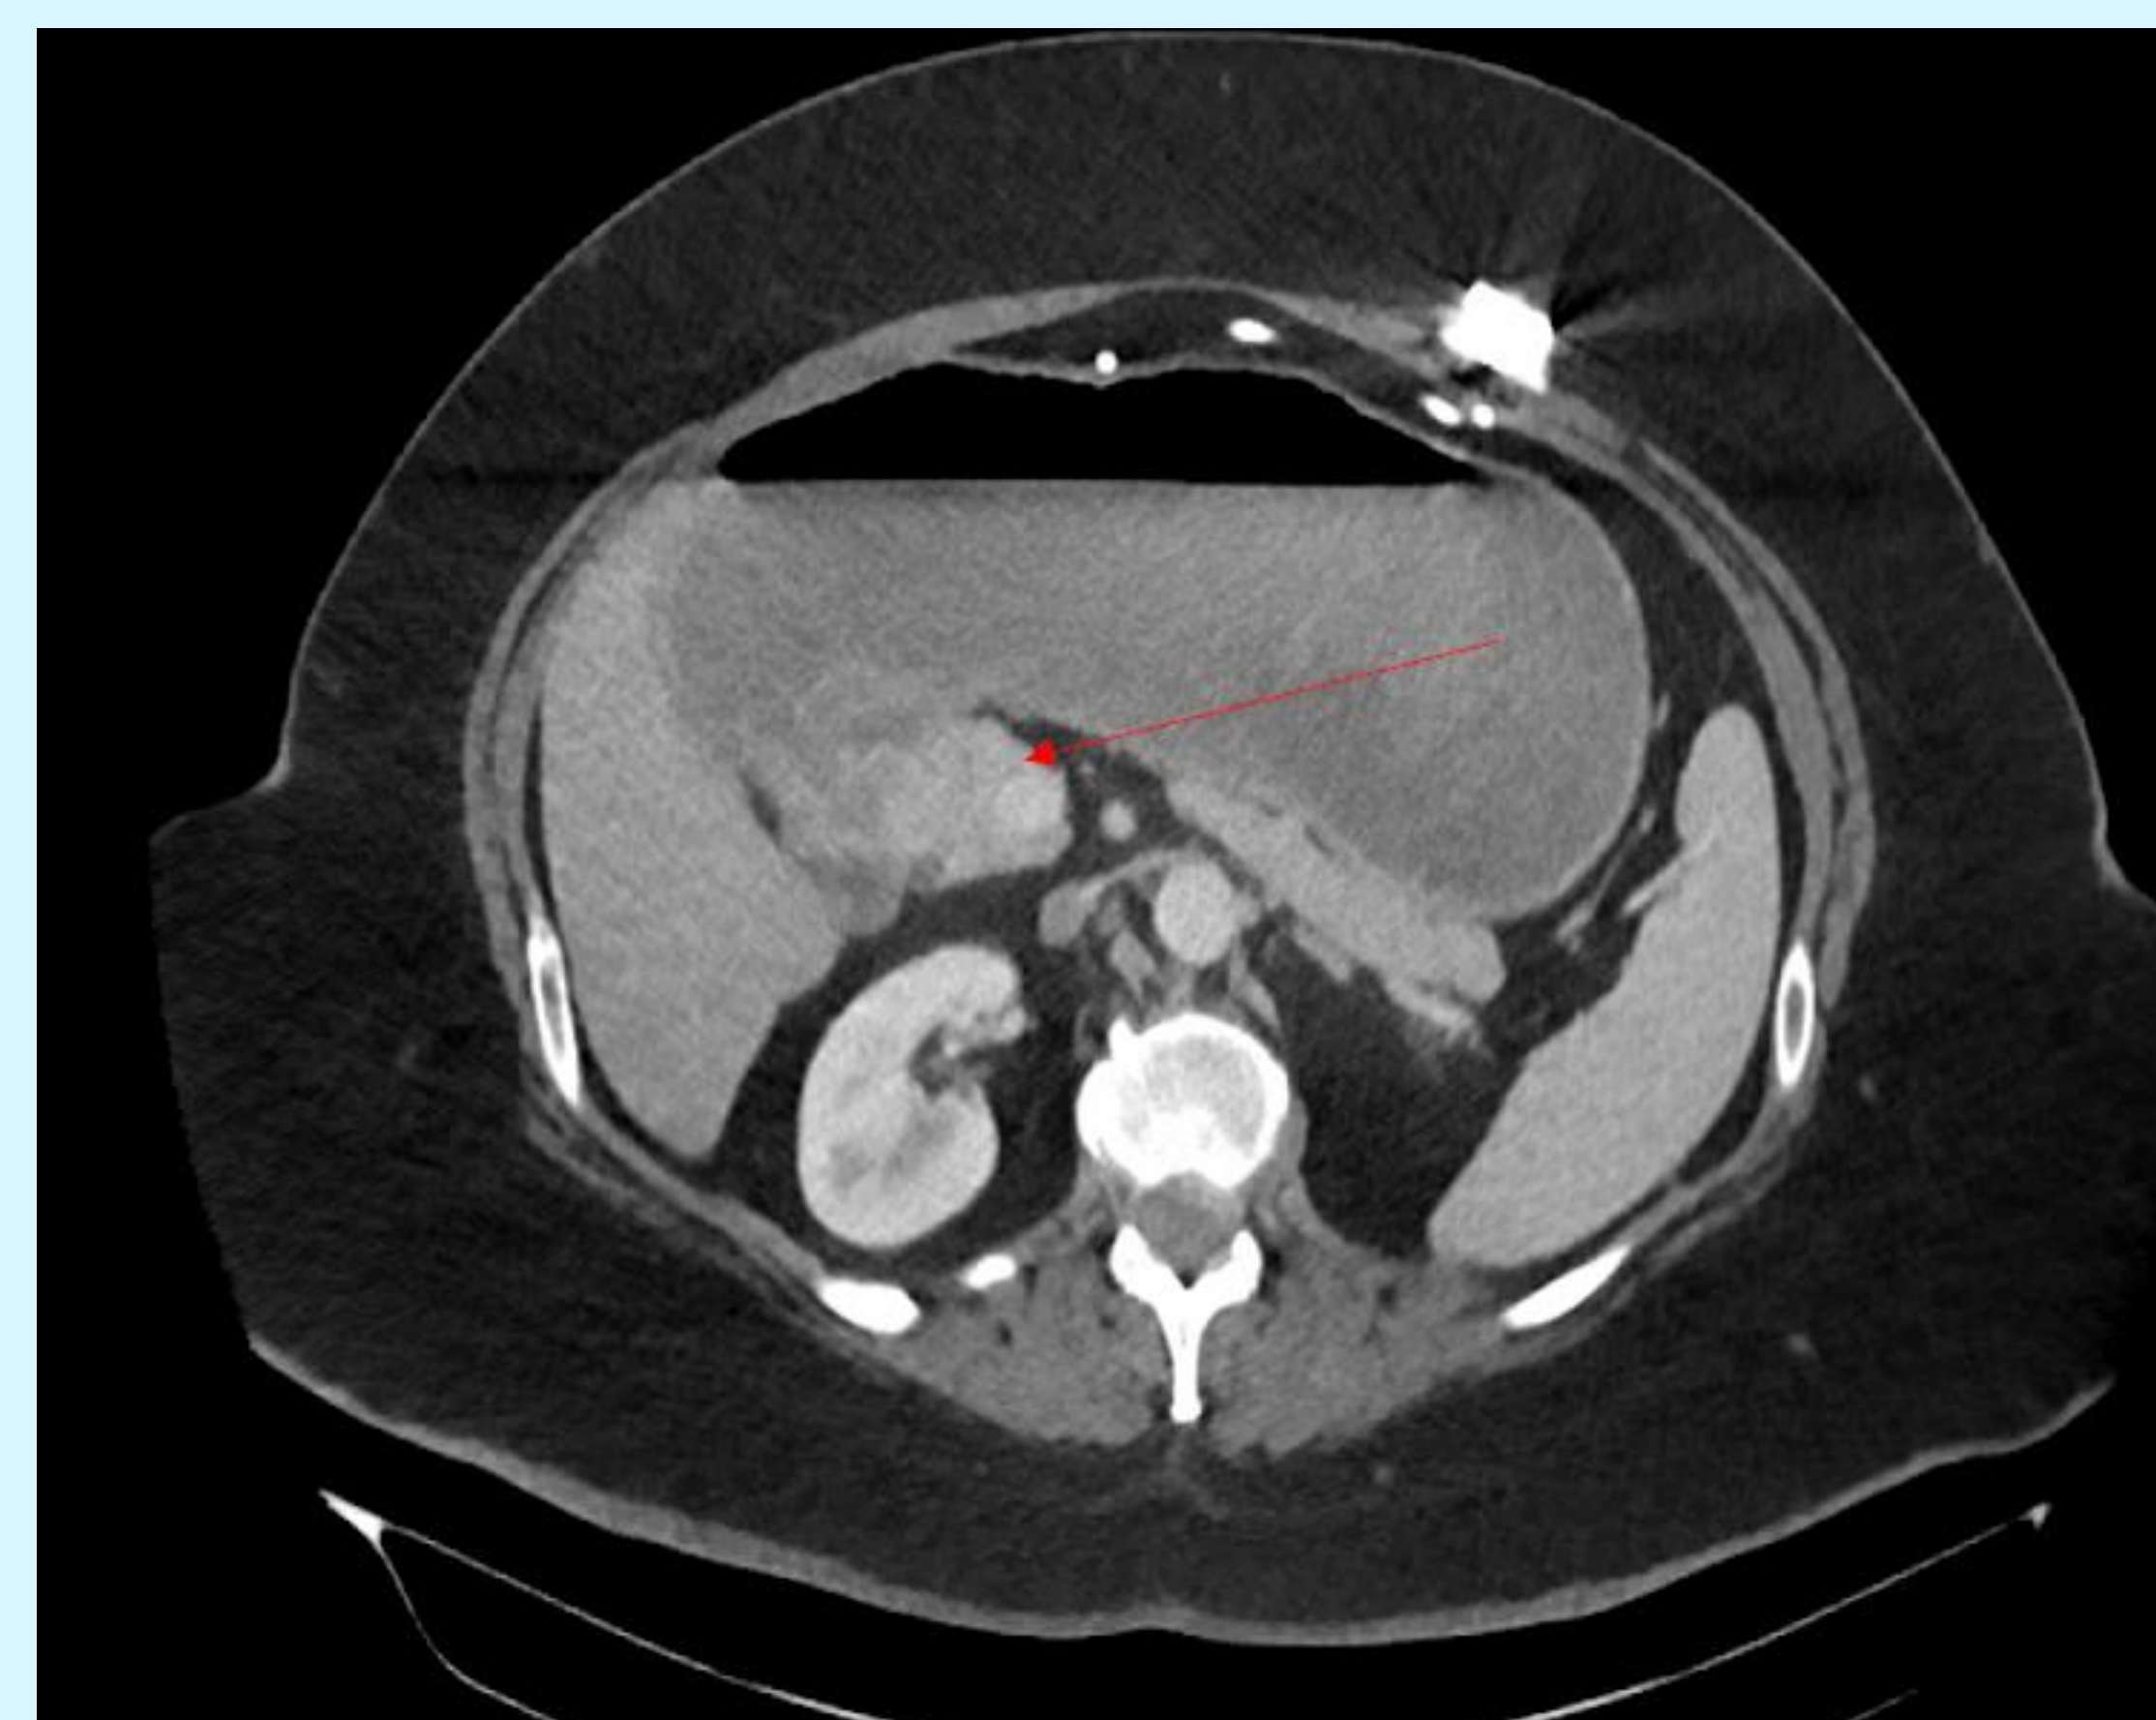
CT demonstration of duodenal bulb mass causing gastric outlet obstruction
